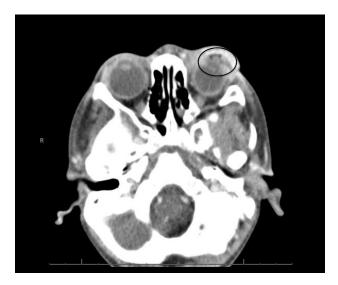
Computed tomographic scan of the orbits demonstrating crescentic hypodense fluid surrounding the tiny bubbles of gas in the left superior eyelid concerning for additional rimenhancing collection measuring 1.6×0.5 cm.
